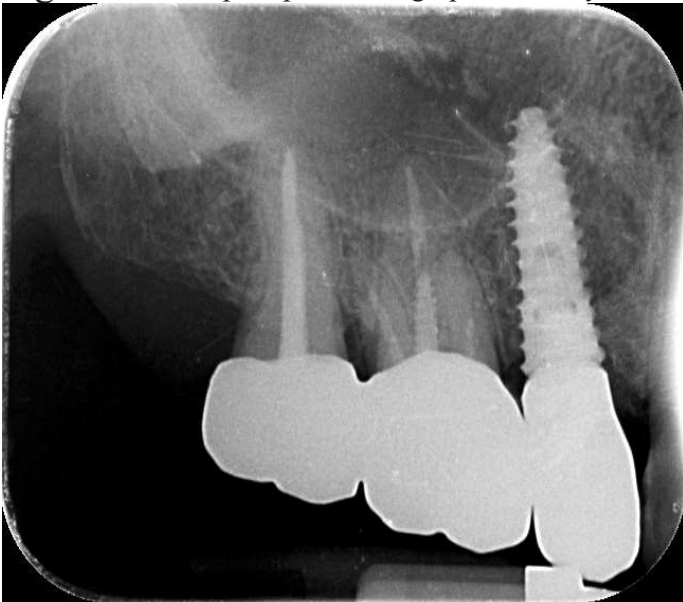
Case 5 (biological complication): periapical radiograph one month after implant placement.
